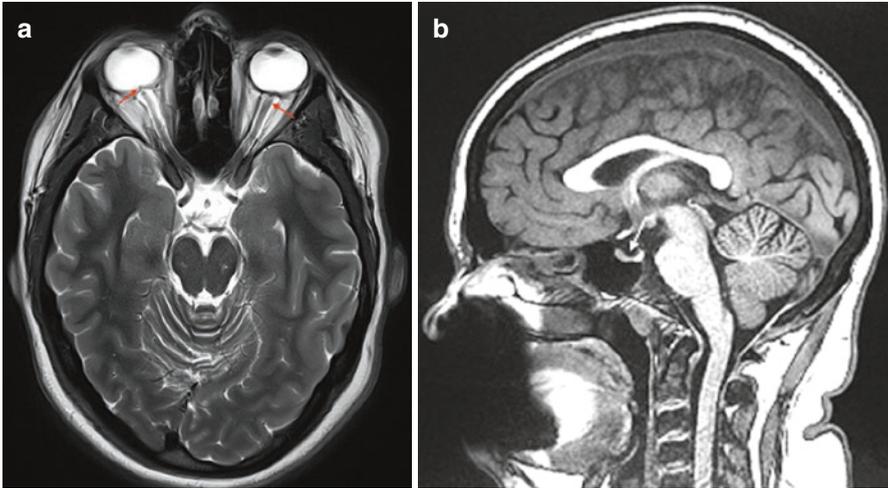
(a) Axial T2 MRI shows evidence of increased intracranial pressure including flattened posterior globe and dilated optic nerve sheaths (*arrows*). (b) Sagittal T1 MRI shows a partially empty sella (*arrow*)
